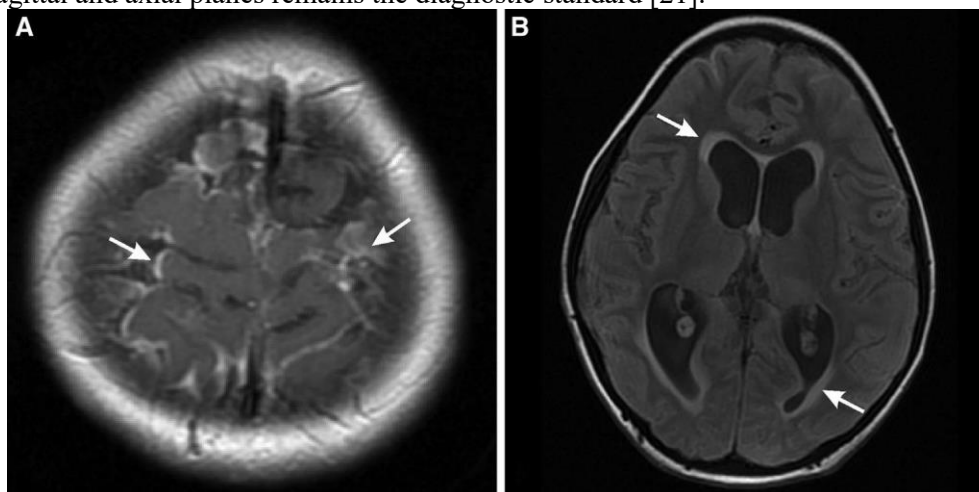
A 9-year-old child with attacks of headache and seizures who had received treatment developed leptomeningeal carcinomatosis with subsequent hydrocephalus. Abnormal leptomeningeal contrast improvements (arrows) are visible in the axial contrast-enhanced T1-weighted magnetic resonance imaging (A). Axial FLAIR MR image (B) shows periventricular interstitial oedema (arrows) and secondary hydrocephalic changes [21].
